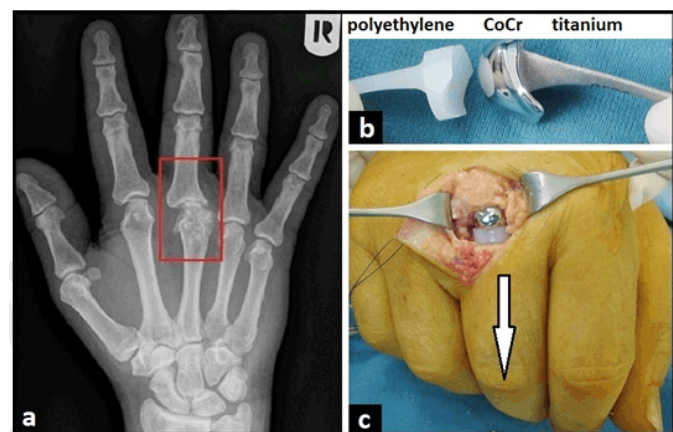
(a) Posteroanterior radiograph showing avascular osteonecrosis of the third metacarpal head accompanied with pronounced metacarpophalangeal joint osteoarthritis (rectangle), (b) Clinical photograph showing both components of SR™ MCP implant, and (c) Clinical photograph showing insertion of implant through the dorsal incision, note that there is a correct alignment of the third finger (arrow).
